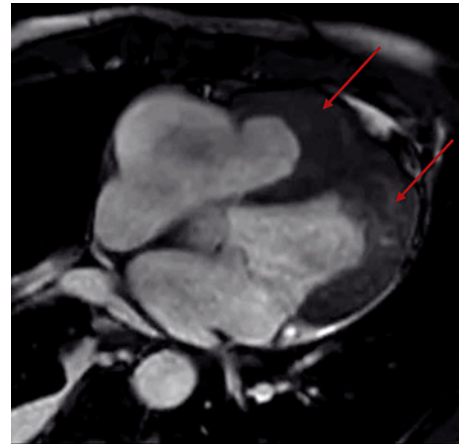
Cardiac MRI demonstrating thrombus-associated obliteration at the ventricular apices and diffuse sub-endocardial necrosis/fibrosis of both ventricles (red arrows).
